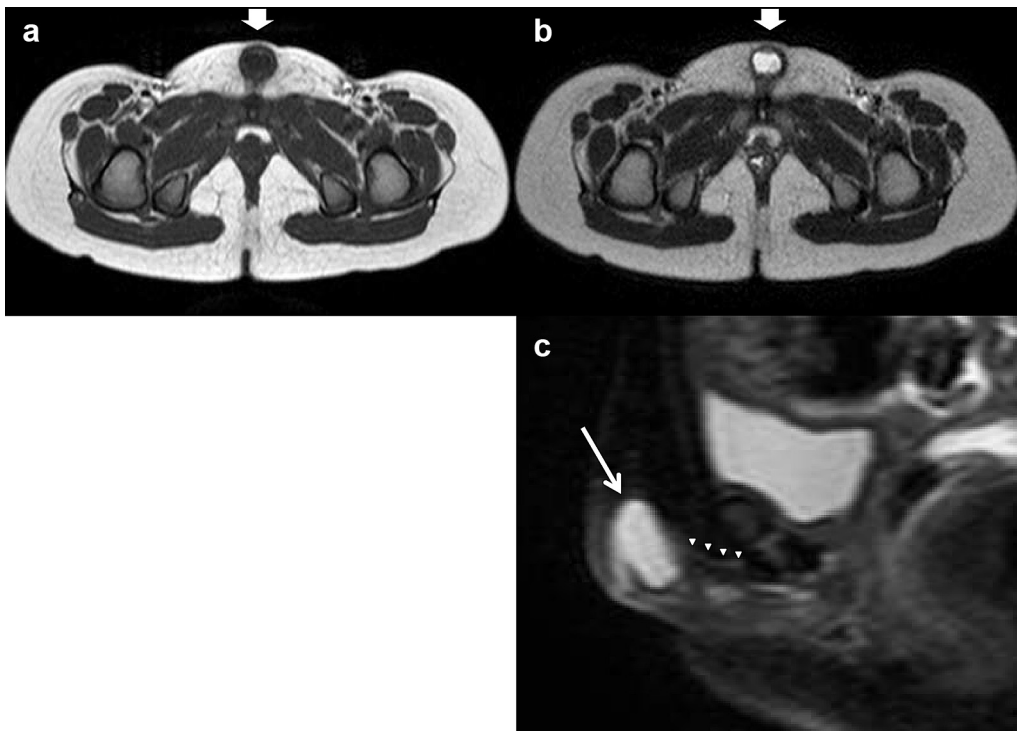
MRI. (a) Horizontal scan of T1-weighted imaging. A subcutaneous cyst (white arrow) is shown. (b) Horizontal scan of T2-weighted imaging. A subcutaneous cyst (white arrow) can be seen. (c) Sagittal scan of T2-weighted imaging. A subcutaneous cyst (white arrow) and thin tract in the subcutaneous layer (white triangle) can be seen.
